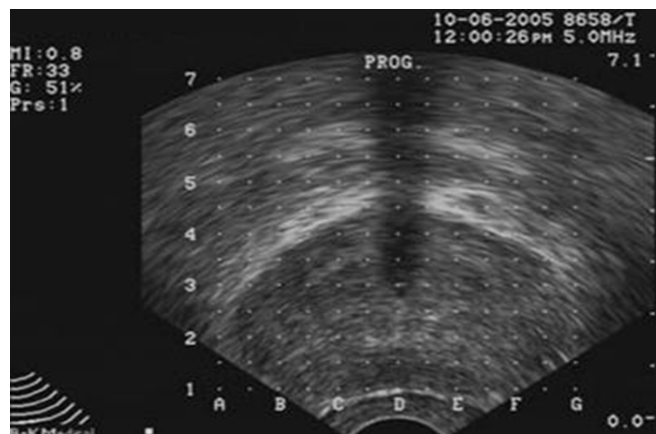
Image {2-5} : Normal sonographic appearance of prostate gland. I Simon, PK Landis 1999.
